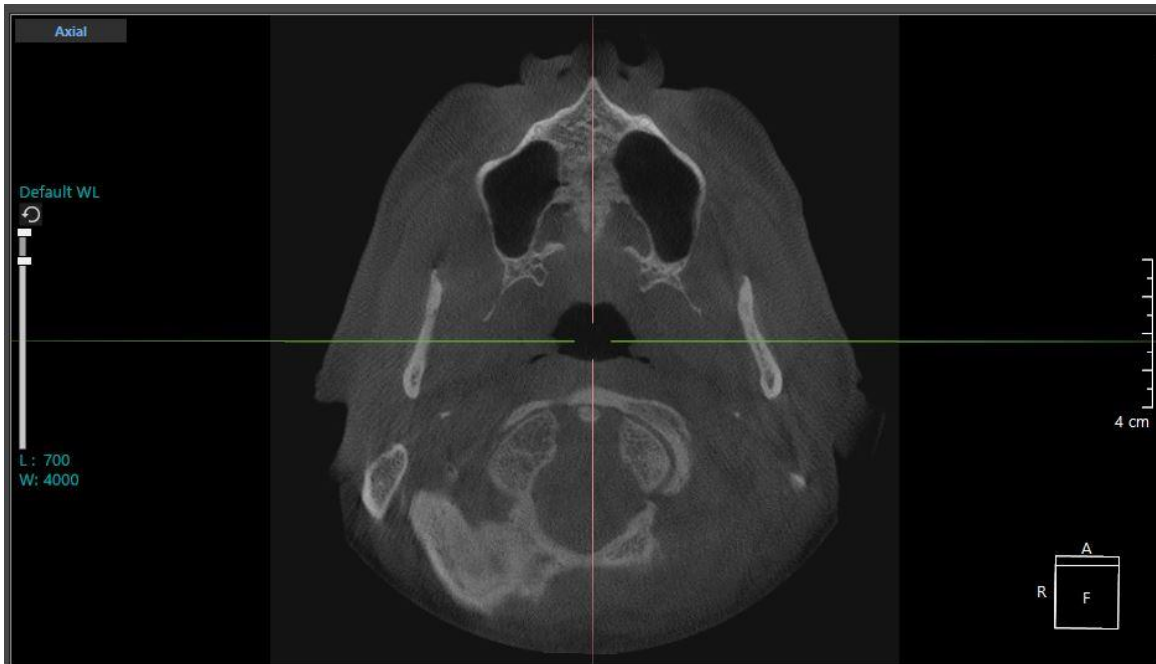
Calibrated CBCT image in the axial view with the red line of the calibration tool being parallel and intersecting through ANS and PNS.
